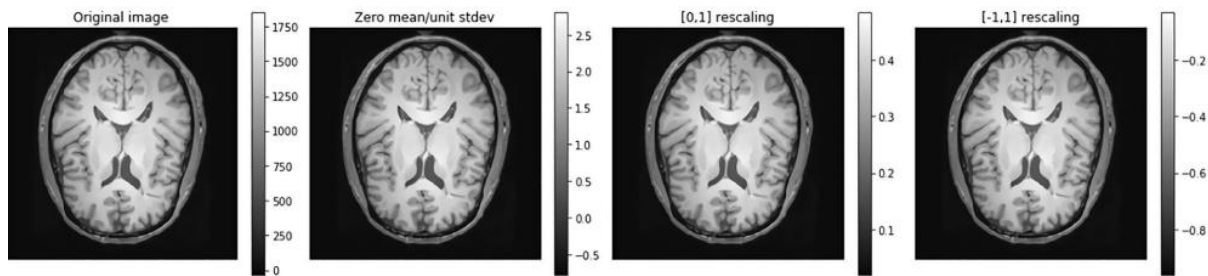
Example of the normalization methods applied on MRI image
